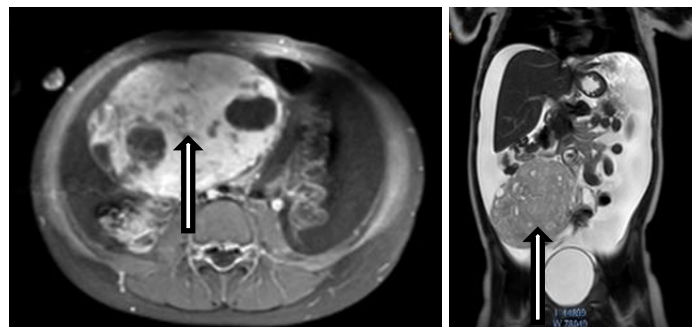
The axial view of an abdominal MRI (Arrow: mass) Figure 4: The coronal view of an abdominal MRI (Arrow: mass)
